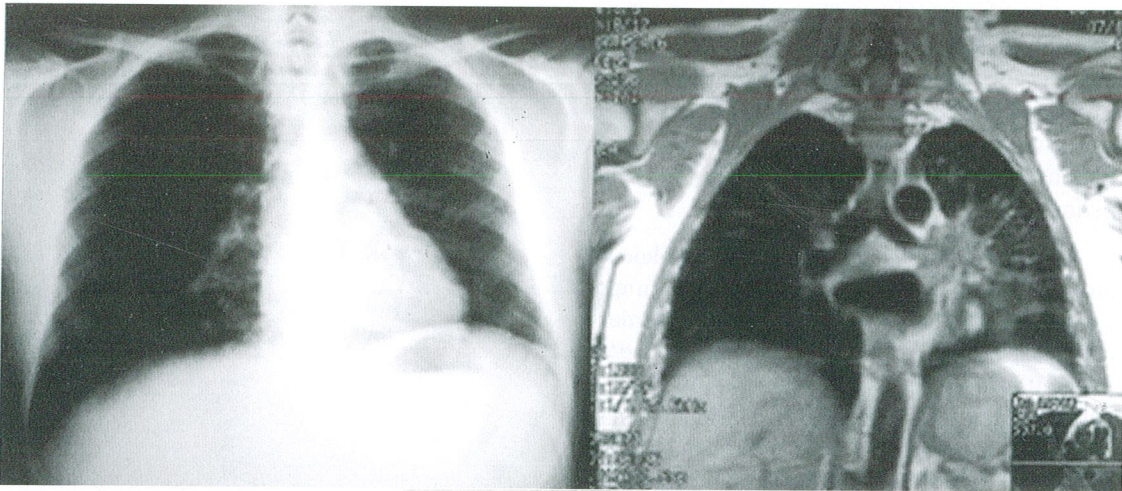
A,B: a- Chest x-ray and b-MR imaging of the second patient.
